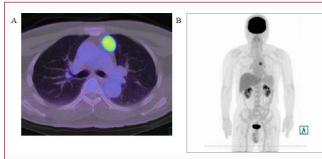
FDG-PET images reveal an anterior Mediastinal tumor with high FDG accumulation with a standardized uptake value max (SUV max) of 9.9, with no other abnormal FDG uptake, including the testes (A, B).
